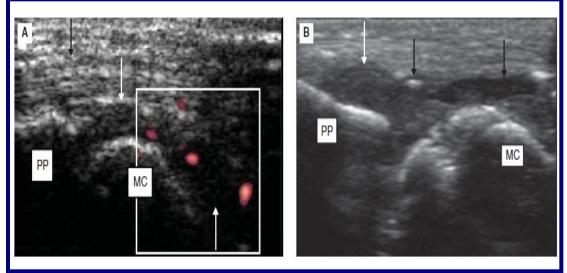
Flexor aspect of MCP joint showing hypoechoic synovial hypertrophy with moderately increased vascularity on power Doppler (image A, white arrow). Distended proximal recess (small arrow). Normal flexor tendon (black arrow). B Longitudinal image of flexor aspect of MCP joint after US guided intraarticular steroid injection. Synovial hypertrophy (white arrow). Injected fluid (long black arrow). Echogenic air bubble (small black arrow). MC = metacarpal, PP = proximal phalanx. (6)
